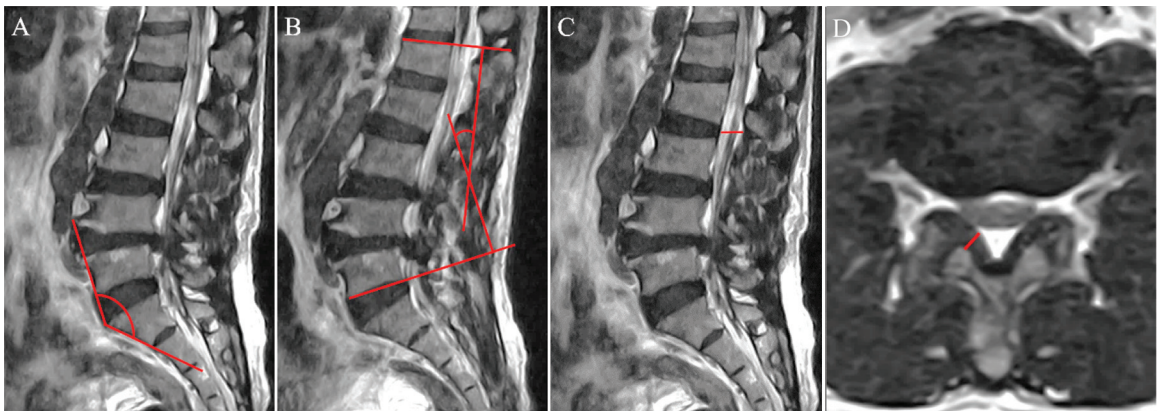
HYCE MRI in sagittal plane with measurement. (A) lumbo-sacral angle, (B) lumbar lordotic angle, (C) AP diameter of spinal canal, and (D) thickness of ligamentum flavum in axial plane.
